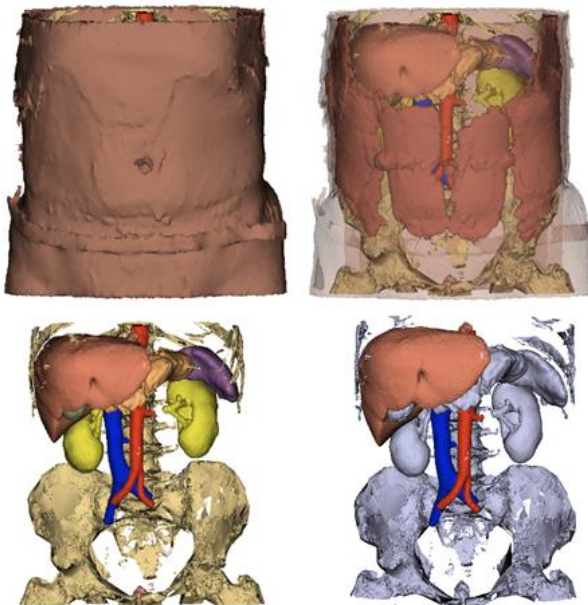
Slicer scenes of abdominal surface rendering models, starting from CT scan of a man, using 3DSlicer modules. It is possible to view the models of the skin of the abdomen (up-left) and put the skin in transparency to show the underlying structures (up-right) and plan the entry point. In the lower part the surface rendering of the organs is shown and the vein and the aorta to be preserved from surgery are highlighted with respect to the target organ, which is the liver.
